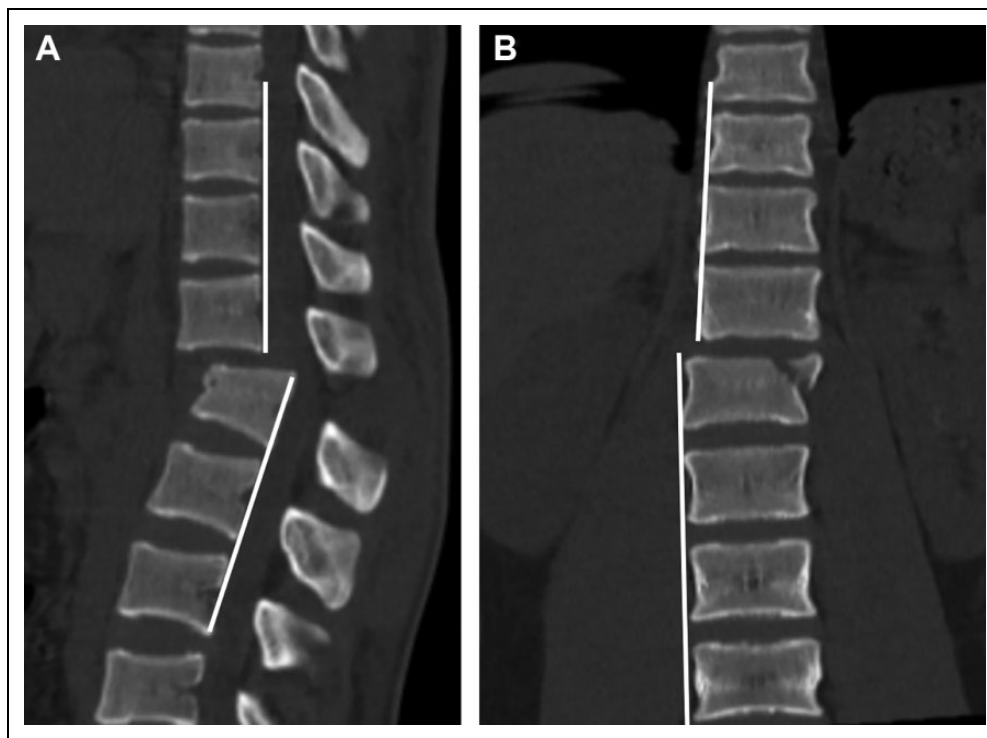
Technique of assessing and measuring vertebral translation in 2 planes: (a) by the presence of translation between 2 adjacent posterovertebral corners in the sagittal CT image or lateral radiograph; (b) the presence of discontinuity between 2 vertical lines drawn along the lateral margins of superior and inferior vertebra in the anteroposterior/coronal view.
